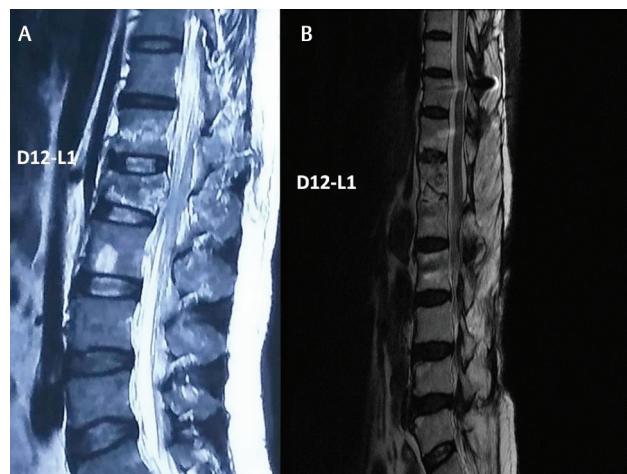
The preoperative (A) and 6 months postoperative (B) MRI picture given along with the radiologic signs of resolution of disease.
